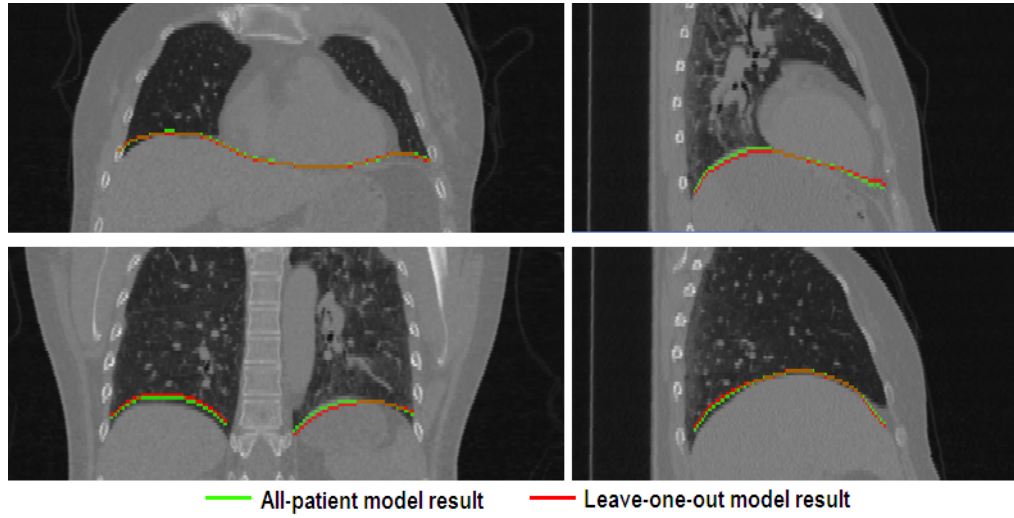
Coronal and sagittal slices through the surfaces obtained by fitting the all-patient model (green) and the leave-one-out model (red) to patient B1 using the PETCT landmark set. These slices are from the end-exhale frame, which is at the opposite extreme of the respiratory cycle from the reference frame, for which the single CT frame was used.
